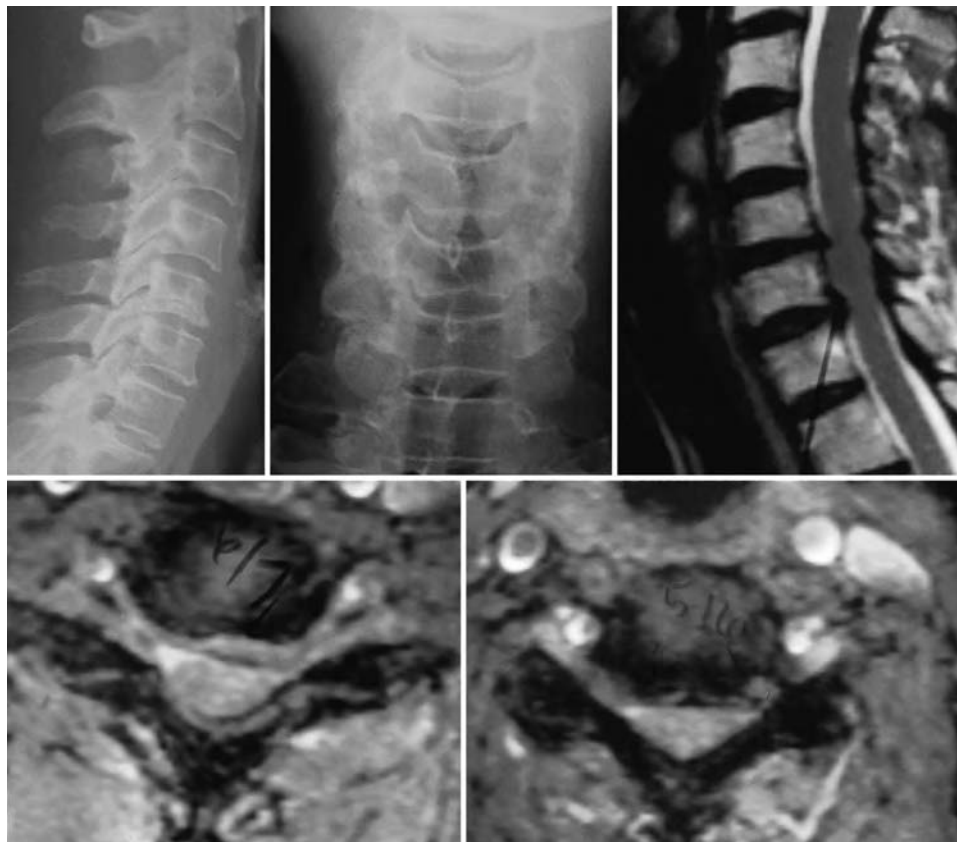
Preoperative imaging studies. Lateral (*upper left*) and AP (*upper center*) radiographs and sagittal MR image (*upper right*). Axial MR images at C5–6 (*lower left*) and C6–7 (*lower right*).
